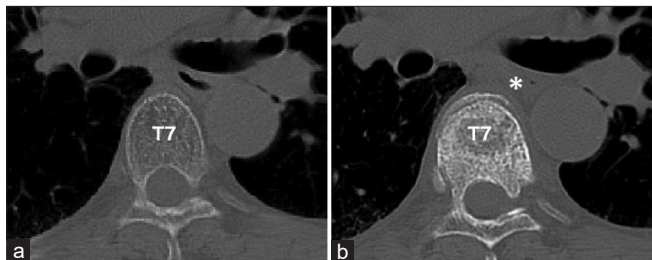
(a) Initial chest computed tomography (CT) showed no obvious abnormal findings. (b) No air in the esophagus was seen on CT 2 months after onset (asterisk).
